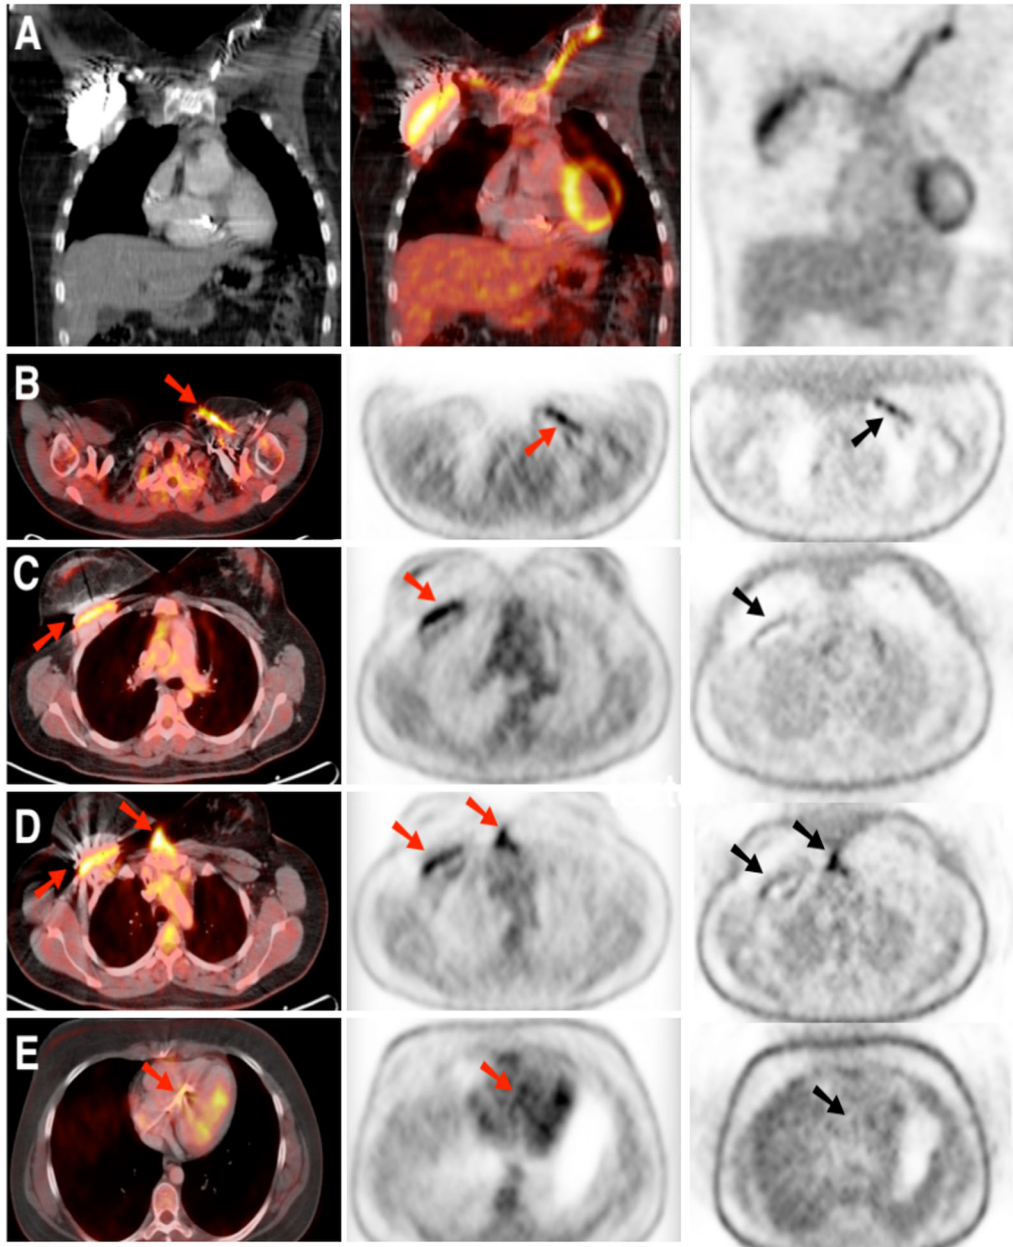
PI documented by PET/CT. (A) Coronal CT (left), PET/CT (center) and PET (right) images displaying a positive study for PI. (B) Axial PET/CT image (left), attenuated-corrected (AC) PET image (center) and non-attenuated-corrected (NAC) PET image (right) showing intense ¹⁸F-FDG uptake along the subcutaneous pathway of the electrode (red and black arrows, respectively) and in the generator pocket (images C and D). Persistent radionuclide uptake in NAC images suggests an active inflammatory/infectious process, ruling out overcorrection artifacts. (E) Mild uptake in the intracardiac portion of the electrode in the AC image (left and center, red arrow) without ¹⁸F-FDG uptake in NAC image (right, black arrow) must be interpreted as an overcorrection artifact. *PI*, pocket infection.
